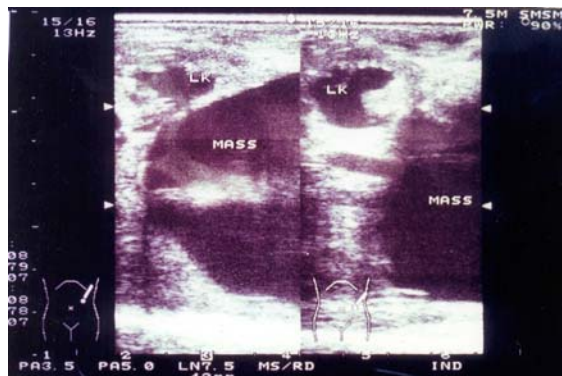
Ultrasonography of abdomen: large cystic mass with hydronephrosis
